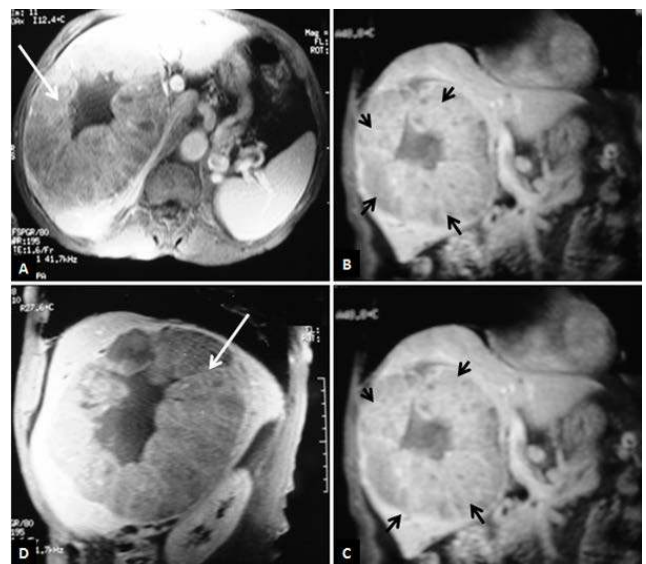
3D T1-weighted hepatic MRI with contrast injection (different vascular times: early arterial (A), late arterial (B), late portal (C), and delayed phase (D)): heterogeneous aspect of the hepatic tumor (white arrow) with extensive arterial blood supply (black arrows)
